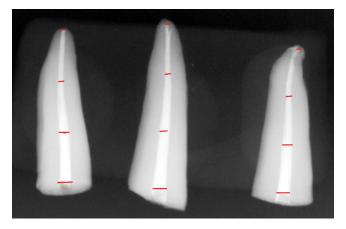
Digital radiograph divided by thirds at buccolingual direction
